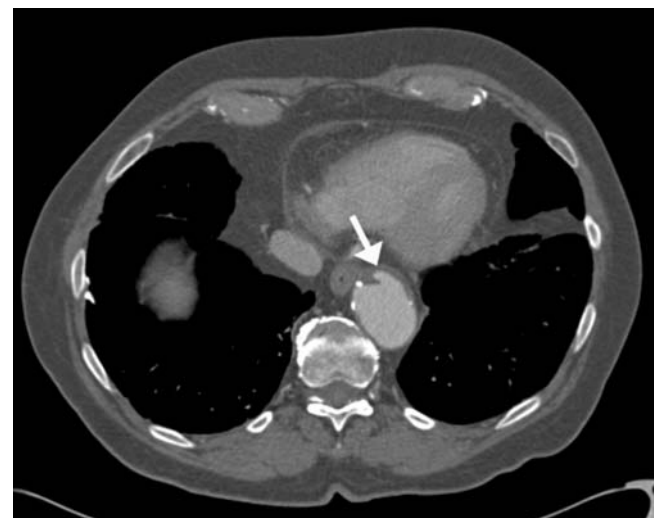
A 74-year-old male undergoing computed tomography for abdominal pain. Axial multidetector computed tomographic angiography through the lower descending thoracic aorta demonstrates a small outpouching from the thoracic aorta into the aortic wall consistent with an anterior small penetrating ulcer (arrow).
